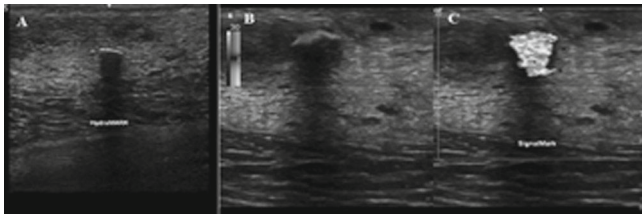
Ultrasound images of A) HydroMARK and B) Signalmark in standard B-mode ultrasound, as well as C) Signalmark viewed with Doppler ultrasound.
